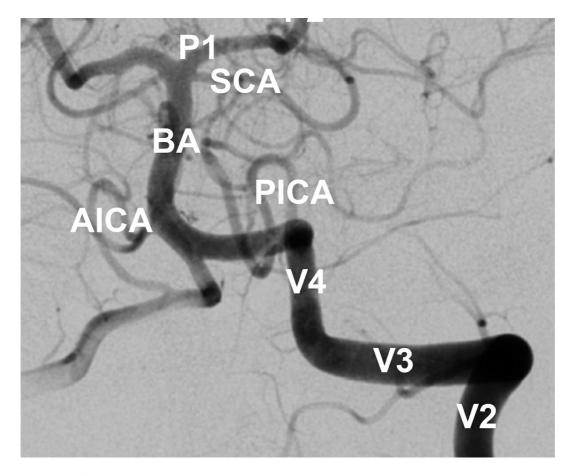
(Top) Reconstruction of CT angiogram demonstrating the circle of Willis and its more distal branches. (Bottom) The distal cervical and intracranial posterior circulation as seen with DSA.
